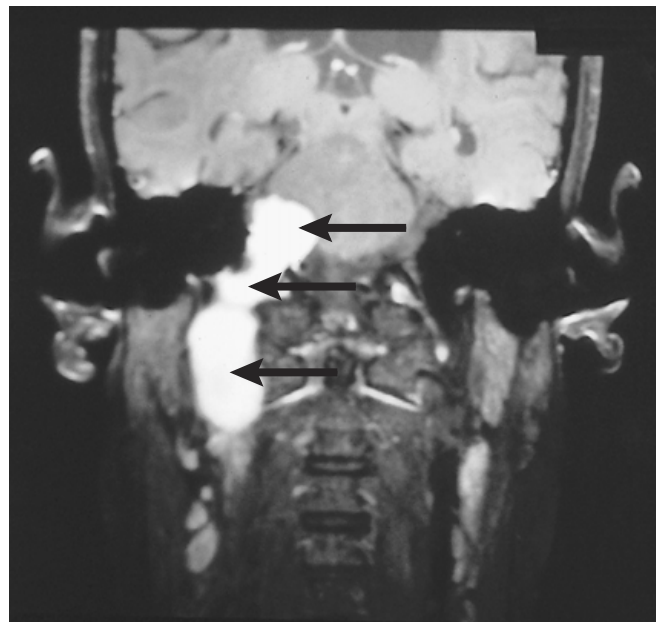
Coronal magnetic resonance imaging view of a vagal nerve schwannoma with the intracranial (top arrow), jugular foramen (middle arrow), and neck (lower arrow) components of the tumor.
